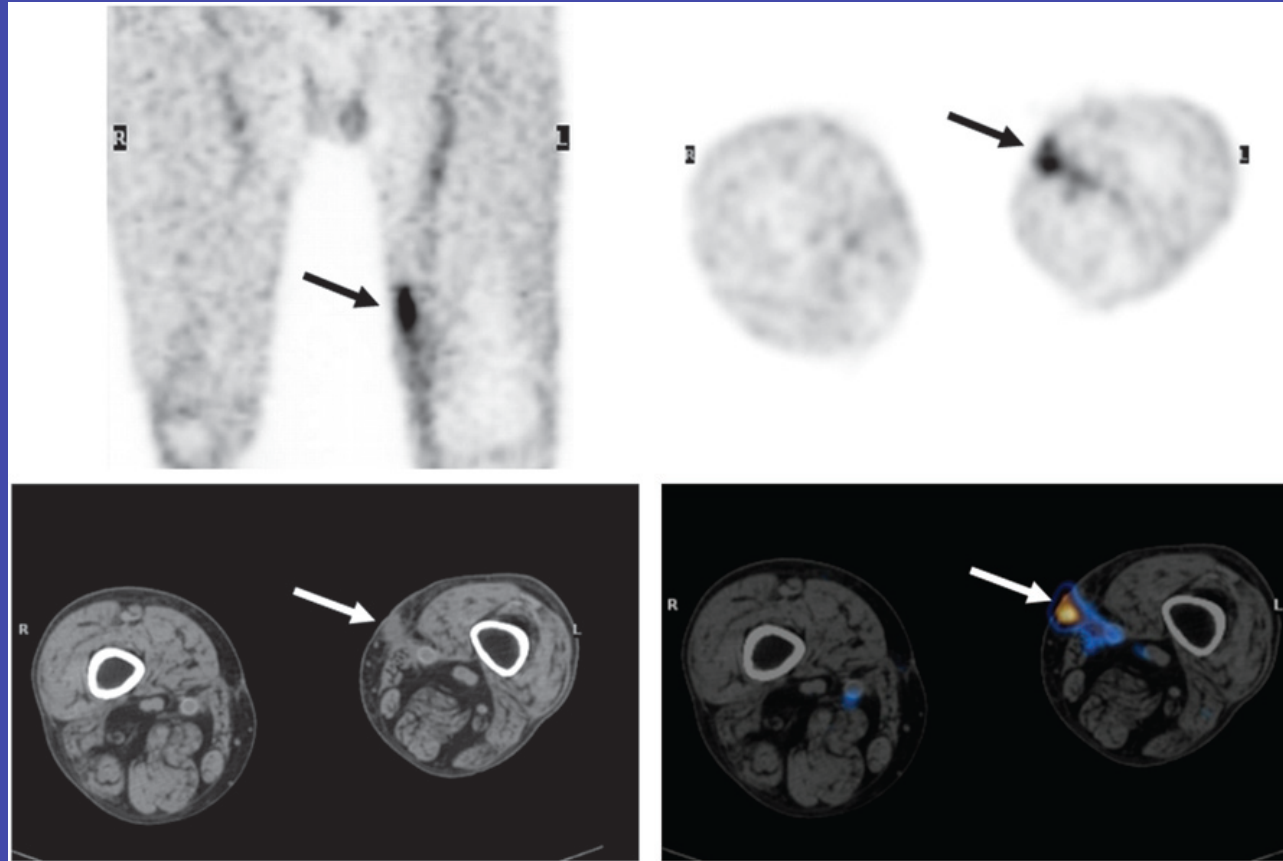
A 68-y-old man who had received left femoropopliteal bypass graft 18 mo previously. Infection was clinically suspected because of fever and infected surgical wound in medial aspect of left distal thigh. Coronal (top left) and transaxial (top right) ^{18}F -FDG PET images show area of increased uptake in (arrows), localized by PET/CT image (bottom right) to soft tissue swelling (arrow) adjacent to left femoropopliteal graft as seen on CT (bottom left). Patient responded rapidly to antibiotic therapy, and no vascular graft infection was evident on long-term follow-up of 14 mo.
